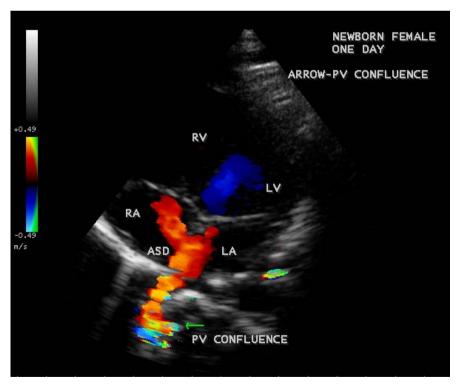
Apical four chamber view showing the coronary sinus type total anomalous pulmonary venous connection in a newborn and a secundum ASD (atrial septal defect). Right atrium (RA) is not dilated and thus differentiated from superior vena cava type total anomalous pulmonary venous connection (SVC type TAPVC) as shown in Figure 15 and Figure 16 in which the right atrium is grossly dilated.
